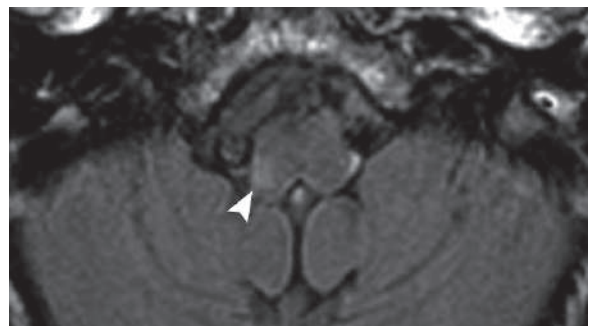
Axial FLAIR image in the region of the medulla in a patient with Wallenberg syndrome (*arrowhead*) shows hyperintense signal intensity lesion in the lateral portion of the right medulla oblongata (*arrowhead*)
